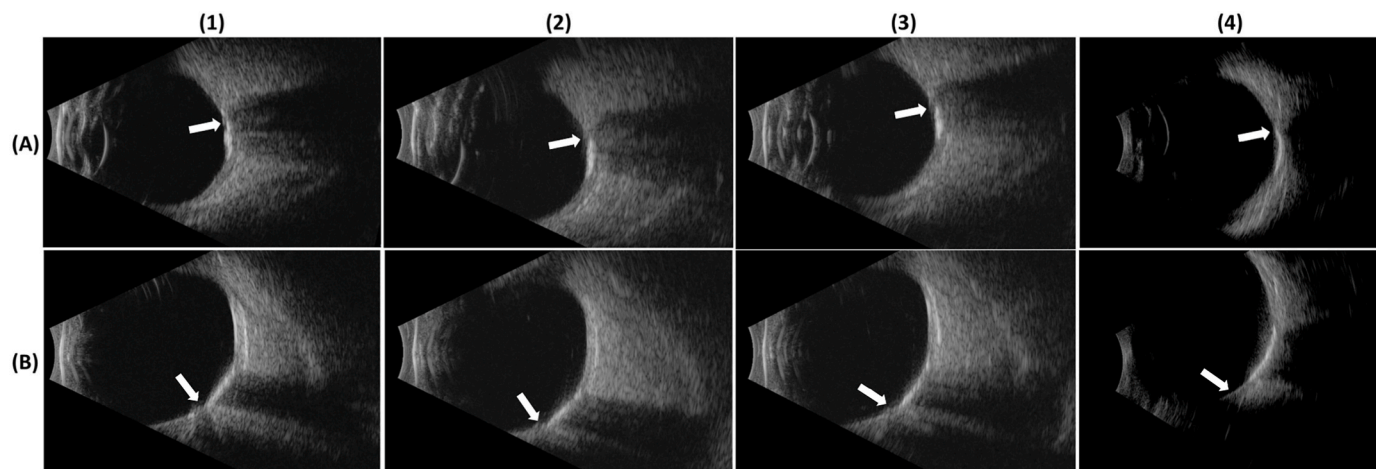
B-scan ultrasound imaging (1–3: 12 MHz and 4: 18 MHz) of the left eye shows stable echogenic plaque-like calcification of the choroid with adjacent posterior acoustic shadowing consistent echographically with choroidal osteoma stabilization over the follow-up period. (A) Horizontal axial view of the left eye showing echogenic plaque temporal to disc indicated by optic nerve insertion (arrows). (B) Longitudinal scan at 3 o'clock of the left eye showing temporal quadrant involvement with peripapillary echogenic plaque and adjacent acoustic shadowing consistent echographically with choroidal osteoma (arrows). (1) Imaging at the start of anti-osteoclastic medications, under alendronate. (2) Four years since start of anti-osteoclastic medications, now under denosumab. (3) Five years since start of anti-osteoclastic medications, under denosumab. (4) Six years since start of anti-osteoclastic medications, under alendronate. Lesion appears brighter due to increased resolution of 18 MHz probe however landmarks suggest stability of lesion.
